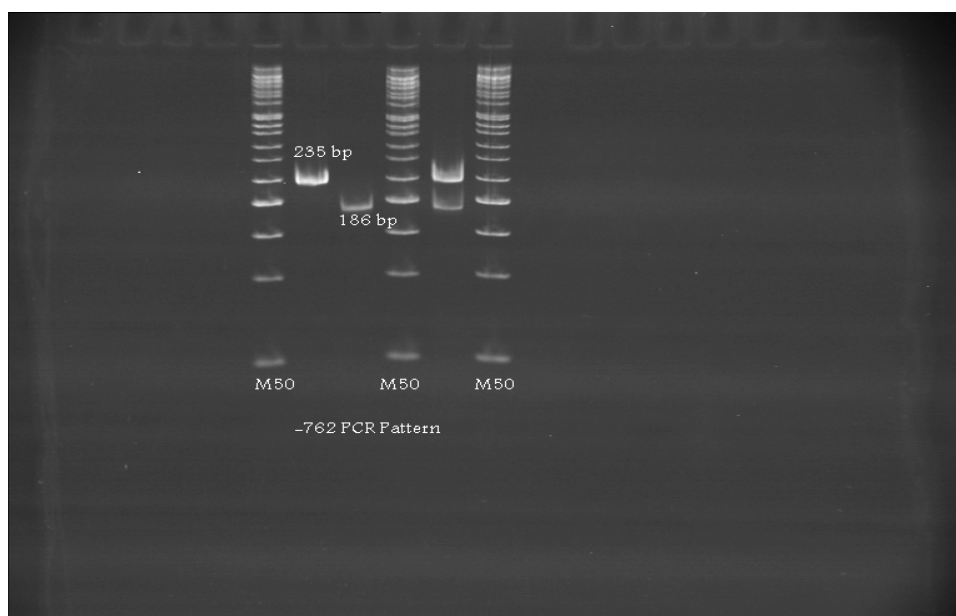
The -762 Amplified PCR Products, CC, CT and TT genotypes had 235 bp, 186+235 bp and 186 bp, respectively
